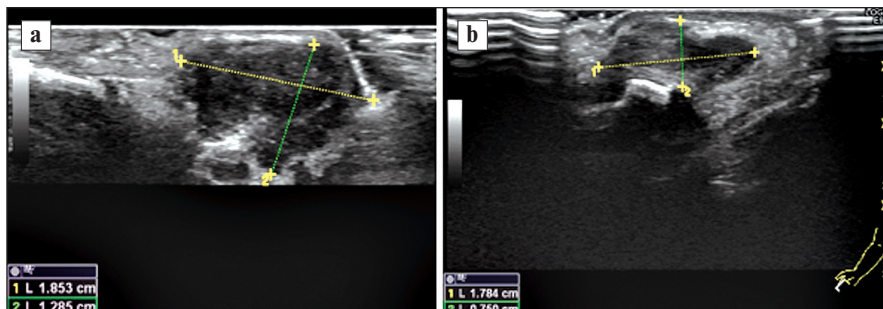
Sonograms of the lesion in the second finger of the hand. Gray scale mode: a – dorsal surface of zone in the second DIPJ; b – palmar surface of zone in the second DIPJ
